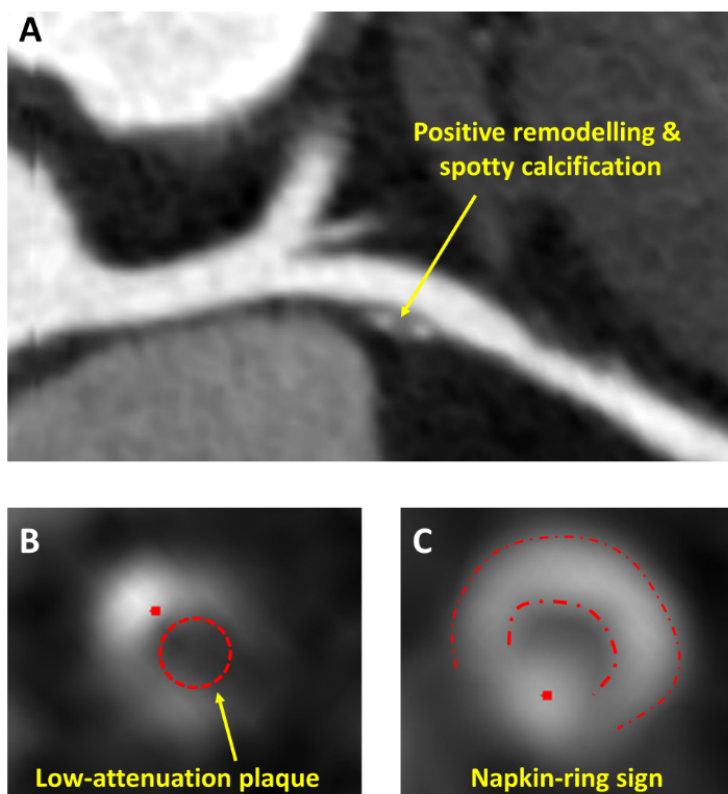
Representative images of high-risk plaque features on CCTA. Panel A demonstrates a coronary plaque with positive remodelling and spotty calcification, panel B shows a lesion with low-attenuation plaque (<30HU), whereas panel C demonstrates a typical “napkin-ring” sign. CCTA: coronary computed tomography angiography; HU: Hounsfield Units.
